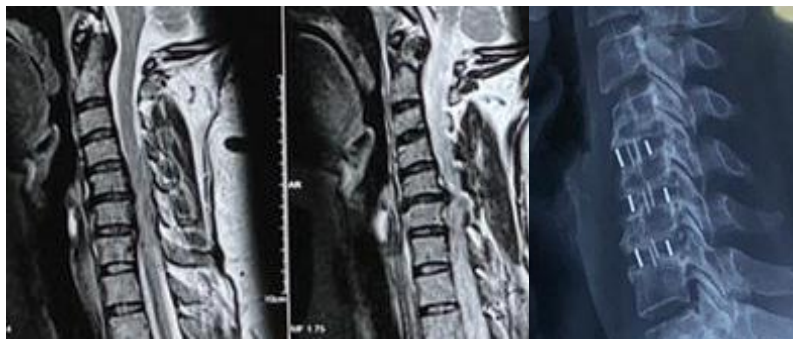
pre-operative MRI and Post-operative X ray of a patient with 3 level ACDF, this patient developed subsidence of 2 cages.
